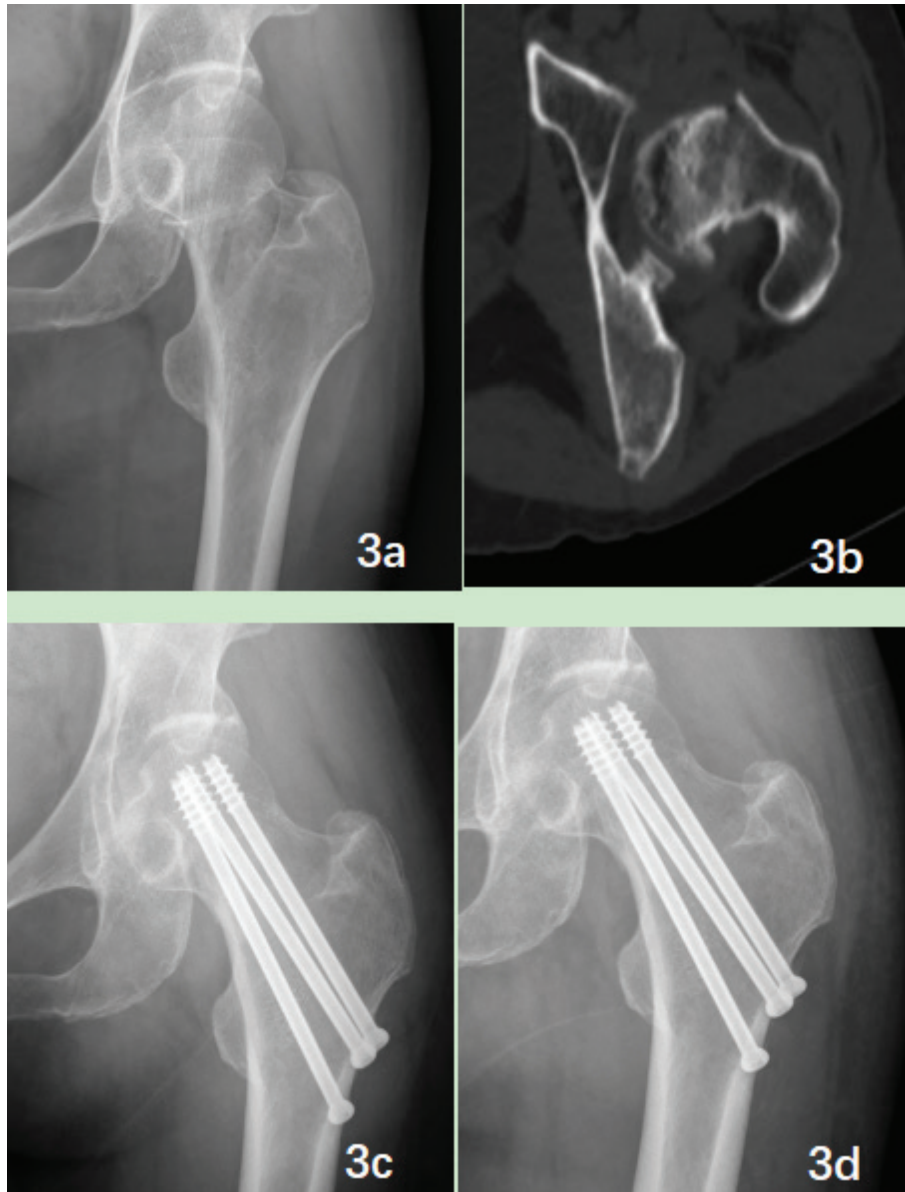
(a and b): Preoperative hip X-ray and CT scan of a 49-year-old male patient with displaced intracapsular hip fracture. (c and d): The 1 year and 2 years postoperative x-ray showed fracture healed without orthopedic complications.
